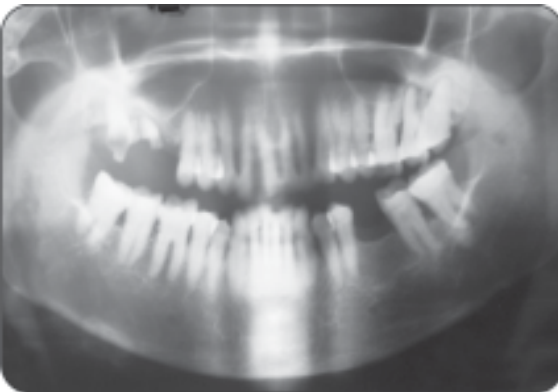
Radiograph of adenoid cystic carcinoma
